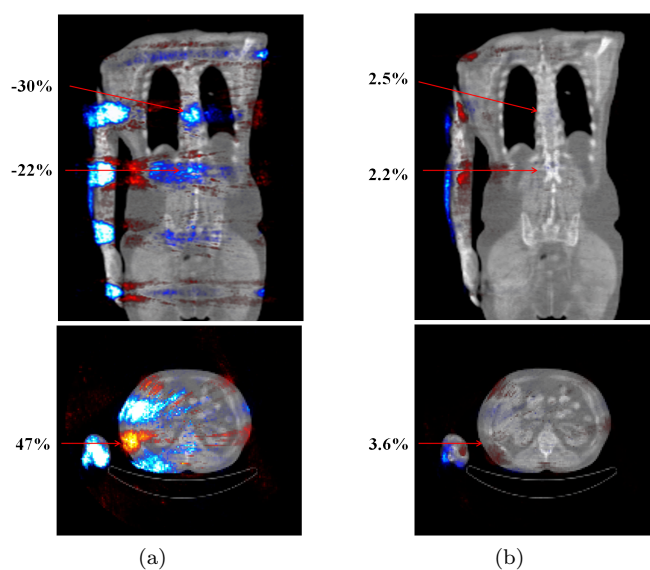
Reconstruction bias overlaid on the original CT attenuation map. PET-reconstruction using the truncated attenuation map (a) and the inpainted attenuation map (b).
